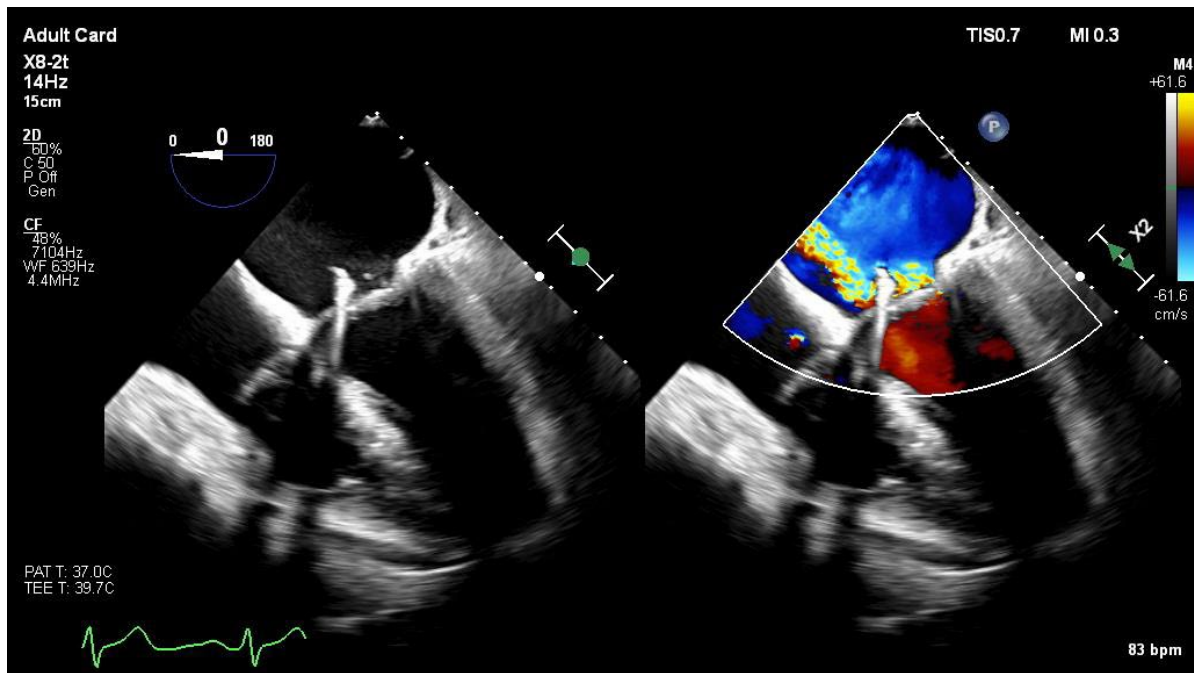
A two-dimensional Transesophageal Echocardiogram (TEE) in the 4-chamber (4C) view with color Doppler displays two regurgitant jets through the mitral valve; however, it cannot differentiate between the jet originating from the valve dehiscence and the jet passing through the valve itself.
